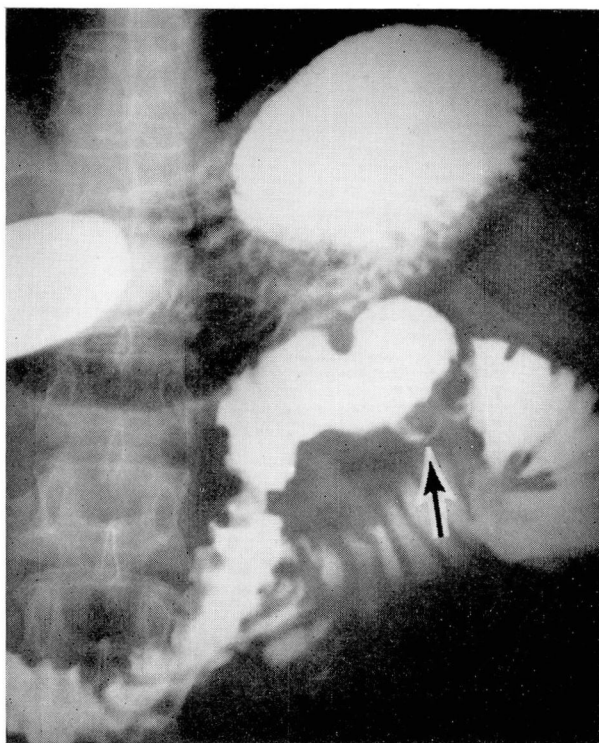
Roentgenogram showing ulceration in the proximal jejunal segment, with a short area of stenosis, in a 45-year-old man with a history of periumbilical pain, diarrhea, vomiting, and tarry feces.
